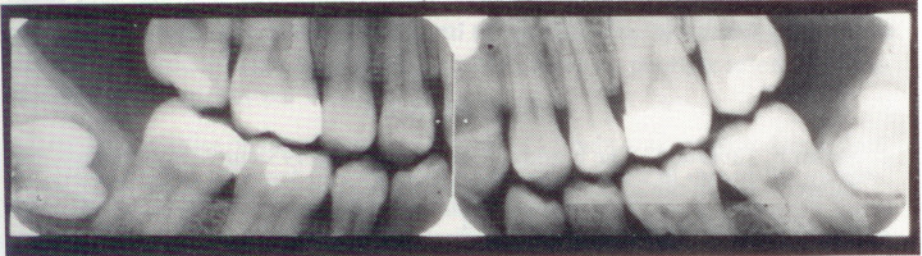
Ante-mortem dental radiographs of patient J.D.F.
